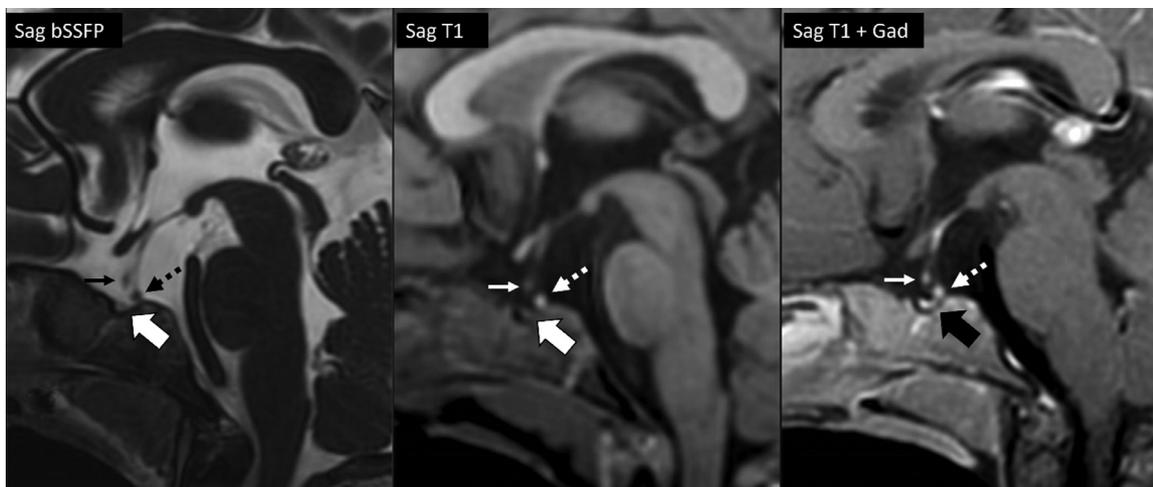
Sagittal images of the sella show pituitary hypoplasia within a hypoplastic sella (thick arrow). The pituitary infundibulum is split in the dorsoventral direction and terminates into 2 small nodules (thin and dashed arrows). The dorsal nodule has the characteristic appearance of the posterior pituitary “bright spot” with intrinsic bright signal (dashed arrow) on the pregadolinium T1-weighted image (center). The ventral nodule does not show intrinsic T1 shortening (center) and demonstrates enhancement (right).
